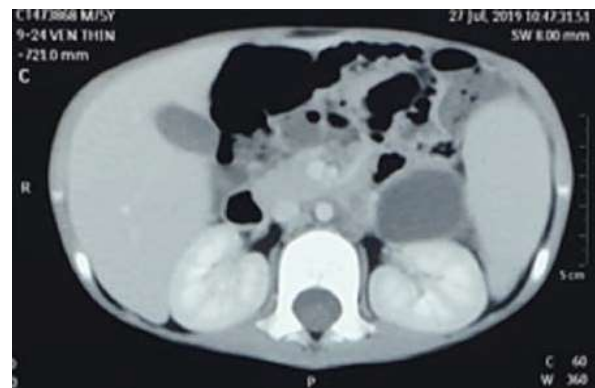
Computed tomography of the abdomen showing a cystic lesion anterior to the left kidney.
